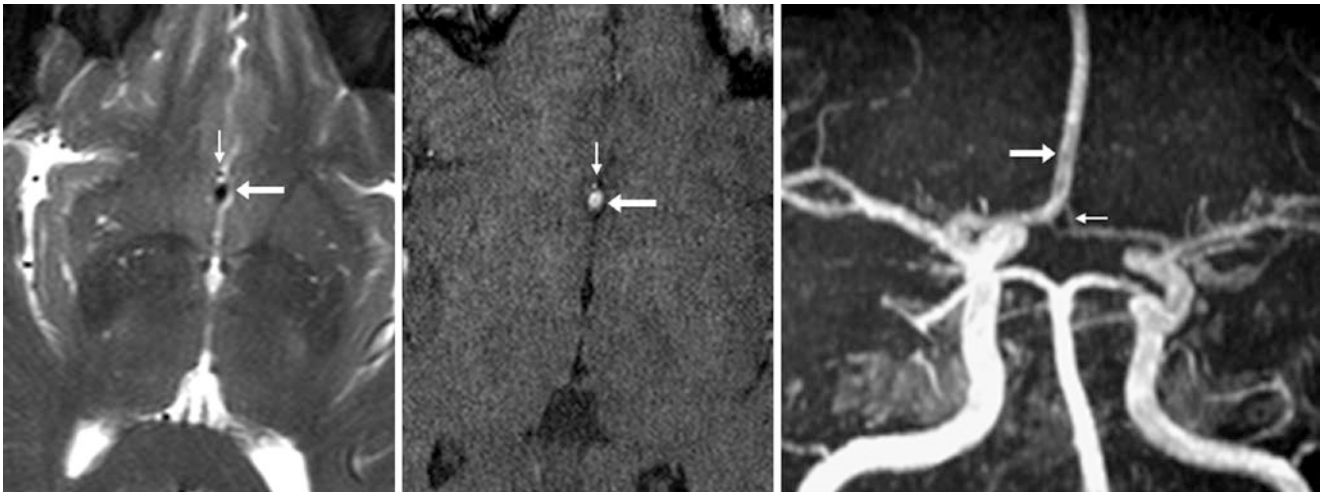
64-year-old with a quite hypoplastic left A2 segment (*thin arrows*) on an axial T2WI MRI (*left*), on a 3DTOF MRA source image (*middle*), and on a 3DTOF MRA MIP AP view (*right*). The dominant
